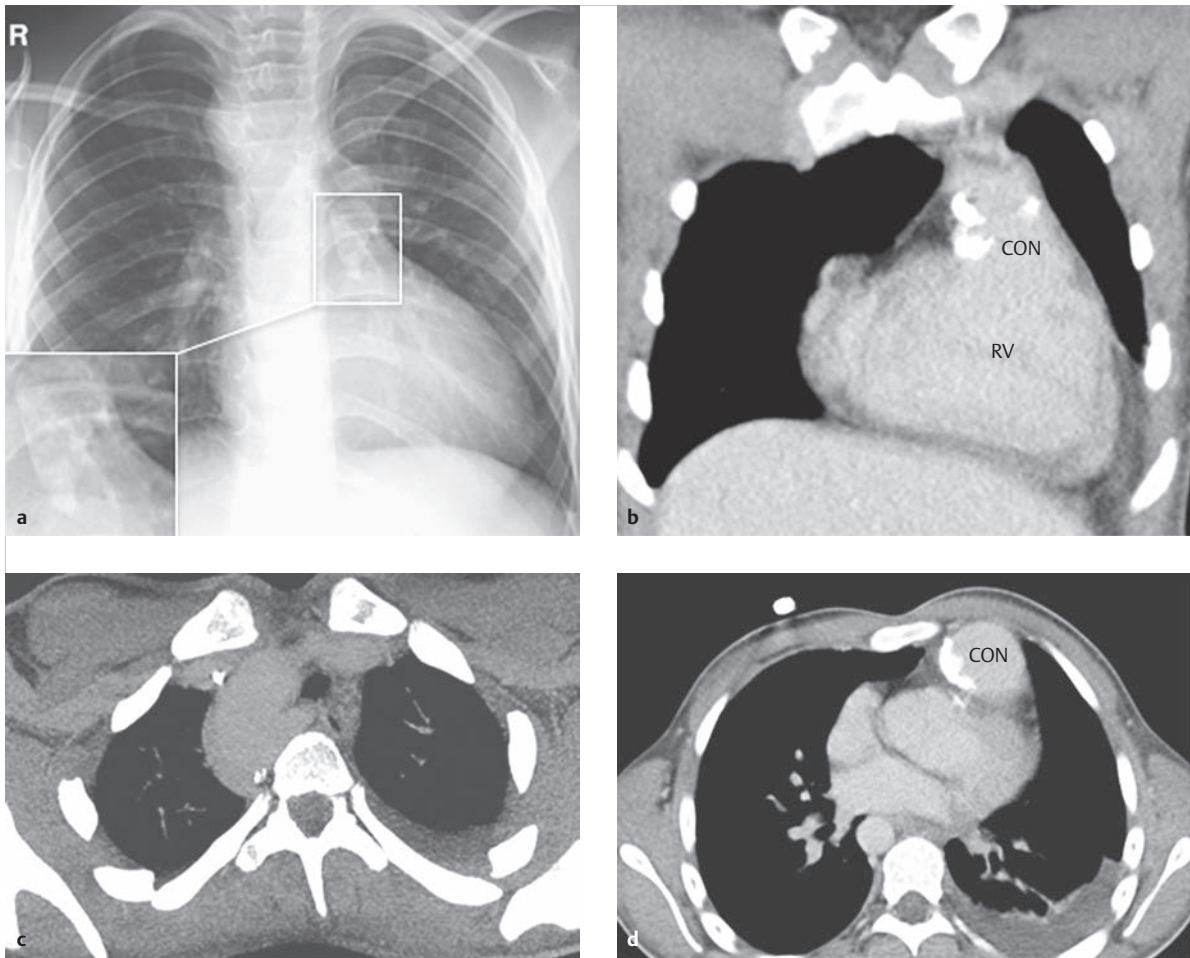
Condition after surgical correction of common arterial trunk and two reoperations due to homograft stenosis. X-rays and CTs of a 17-year-old female patient all depict pronounced calcification near the homograft. Note the right aortic arch in a and c.
